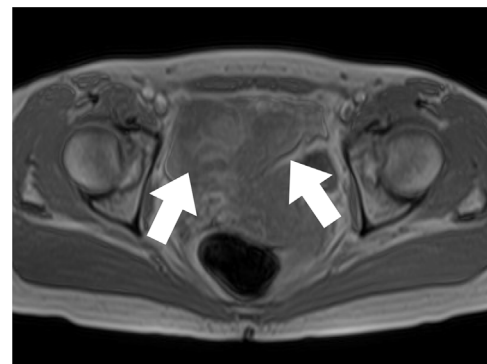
T1-weighted image in the same section as in Fig. 2. The dorsal part of the cystic lesion and outside the cystic lesion to the left showed high-to-mildly high signals and lacked fat intensity, indicative of blood (arrows).
